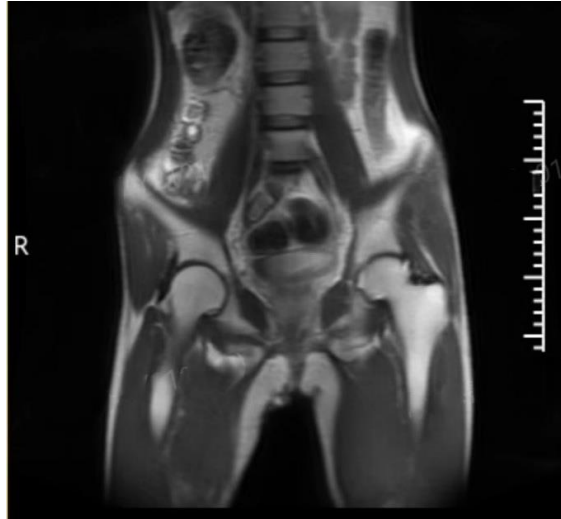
The magnetic resonance imaging of pelvic cavity of case 3 showed uneven thickening of the lower rectum and local thickening of the right perianal skin, anal fistula with small abscess formation
